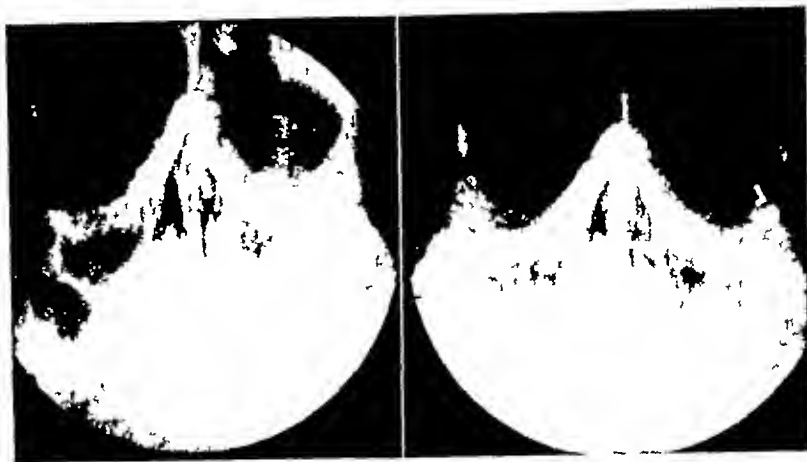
Case 4 Radiograph at the time of treatment showing evidence of a pansinusitis. History of nasal discharge, sinus bronchitis, and recurrent head colds dates back many years.
